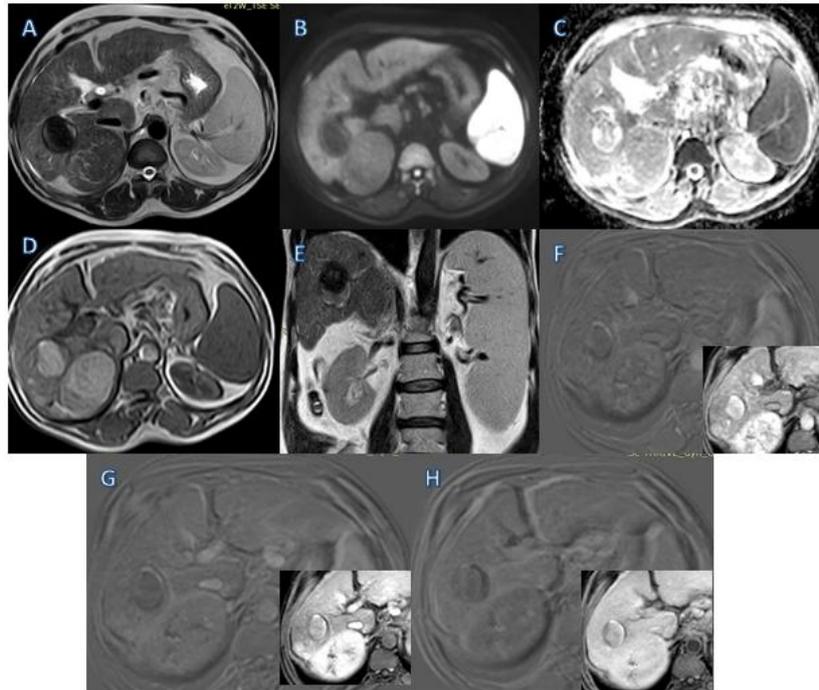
Figures from A to H showing segment VI well ablated HCC as well as liver cirrhotic features and other newly developed HCCs. A: T2 WI eliciting low signal of the HFL. B: DWI eliciting low signal of the HCC. C: ADC eliciting bright signal of the HFL and ADC value 1306×10^{-3} . D: T1 WI out of phase eliciting increased signal of the HFL. E: Coronal T2 WI. F to H: Post contrast dynamic images in arterial (F), portovenous (G) and delayed (H) phases with subtraction images showing no contrast enhancement.
